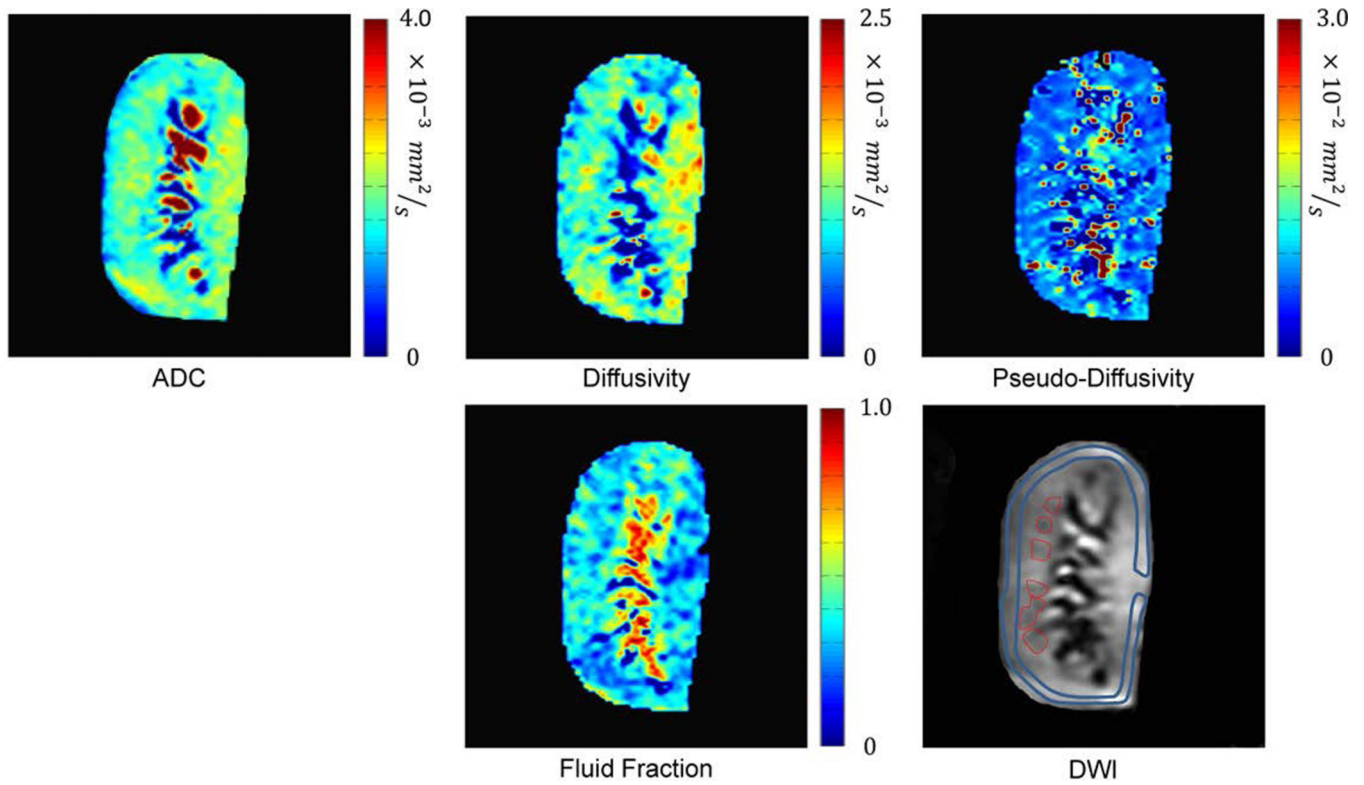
DWI-derived ADC and IVIM maps. ADC, Diffusivity, pseudodiffusivity and fluid-fraction. Cortical (blue) and medullary (red) ROIs were drawn on b_0 DWI images and transferred to the maps.
